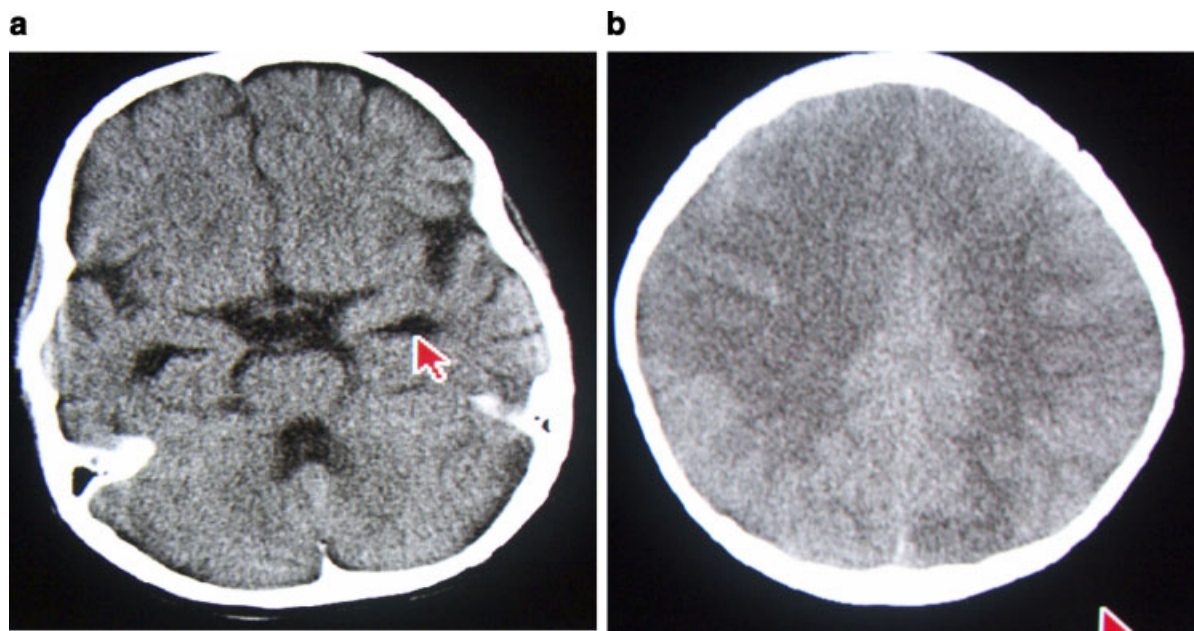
Computerized tomographic (CT) scan images of two CHPV confirmed cases. a: Shows dilated temporal horns of both lateral ventricles (indicated by an arrow) in a section at suprasellar cistern. b: Shows diffuse white matter edema on both sides and effaced sulcal spaces in a section at the supraventricular region.
